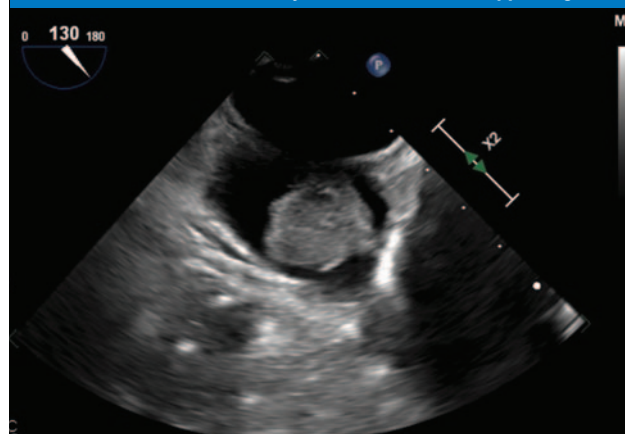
Follow-up transesophageal echocardiogram exhibiting a 2 x 2 cm mobile echodensity within the left atrial appendage.
